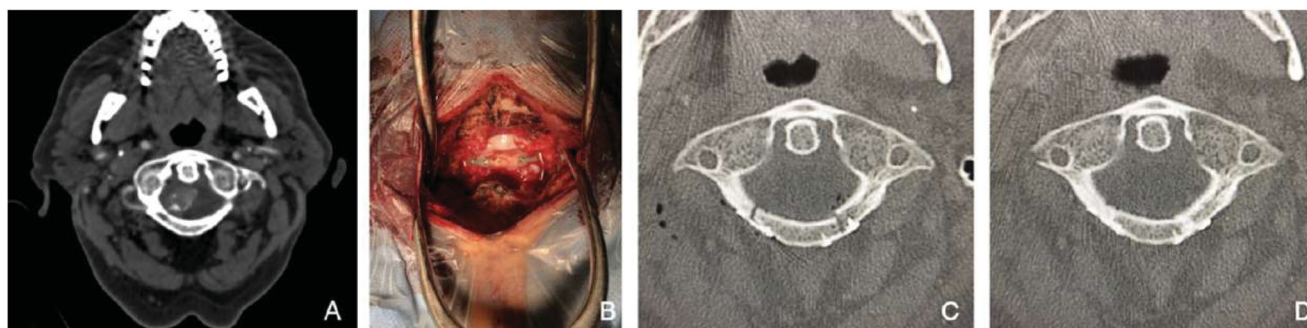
(A) A pre-operative CT scan showing the partially calcified meningioma. (B) Intra-operative reconstruction of the posterior arch with titan plates and screws. (C) C1 reconstruction, post-operative CT scan. (D) One-year follow-up showing the complete ossification of C1 posterior arch.
